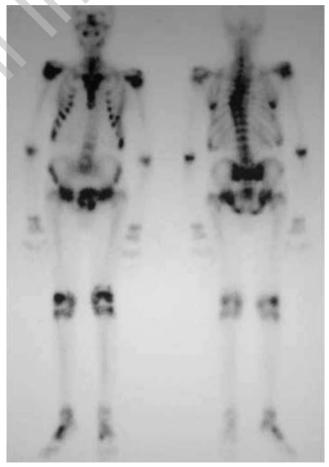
Whole body bone scintigraphy (anterior and posterior views) shows multiple areas of increased uptake in the thoracic spine, ribs, pelvis and limbs. Note the characteristic H-shaped pattern in the sacrum, typical of insufficiency fractures.
